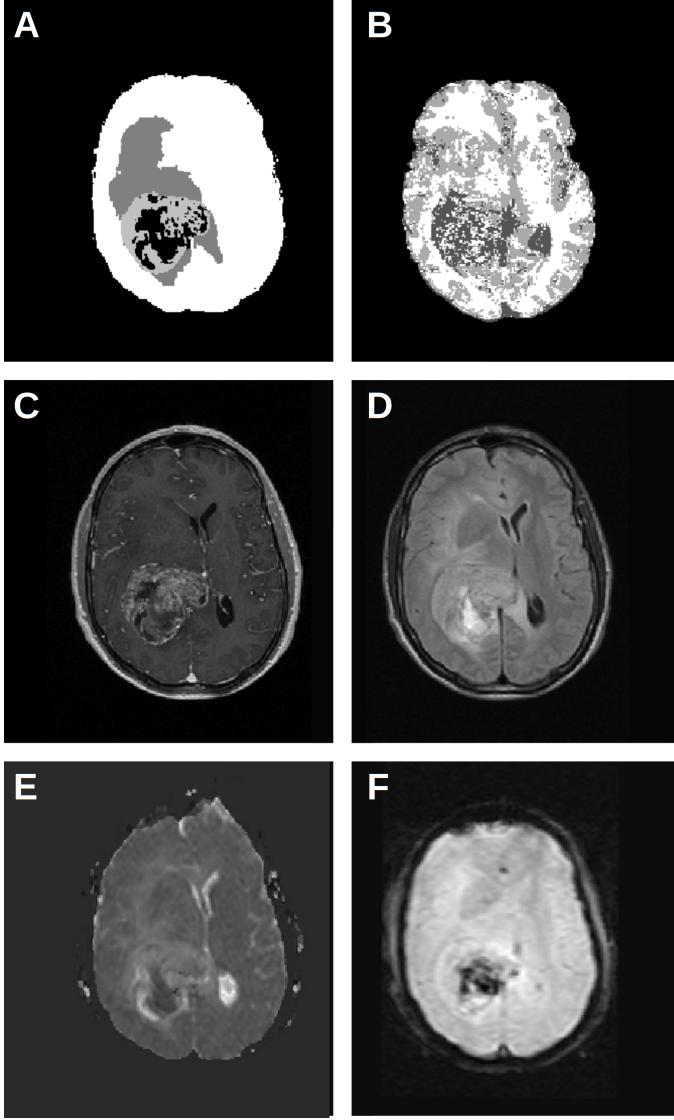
Patient imaging dataset. A DeepMedic segmentation gives brain mask (white), edema (dark grey), tumor (light grey) and necrotic (black) zones. B FAST segmentation gives only grey and white matter zones, as the tumor tissue is partially misinterpreted as CSF (dark grey). C T1-CE method gives the density of solid components (brighter contrast, higher density). D FLAIR method gives the density of fluid components (brighter contrast, higher density). E ADC method gives diffusion coefficient of water (brighter contrast, higher coefficient). F r-CVB method gives the permeability between intra- and extra-vascular space (brighter contrast, higher permeability).
